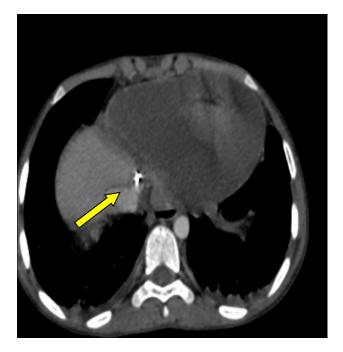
CT abdomen guide wire inside sheath at the junction of hepatic vein and inferior vena cava.
